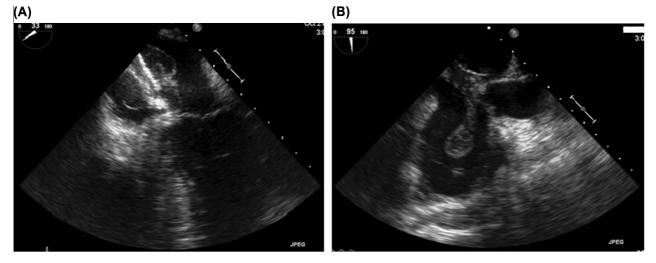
Transesophageal echocardiogram at the mid esophageal level (A at 33° , B at 95°) showing large, multilobulated and mobile echodensities (arrowheads) on either side of the GORE-HELEX septal occluder device (arrow) consistent with vegetations. LA = left atrium; LV = left ventricle; RA = right atrium.
